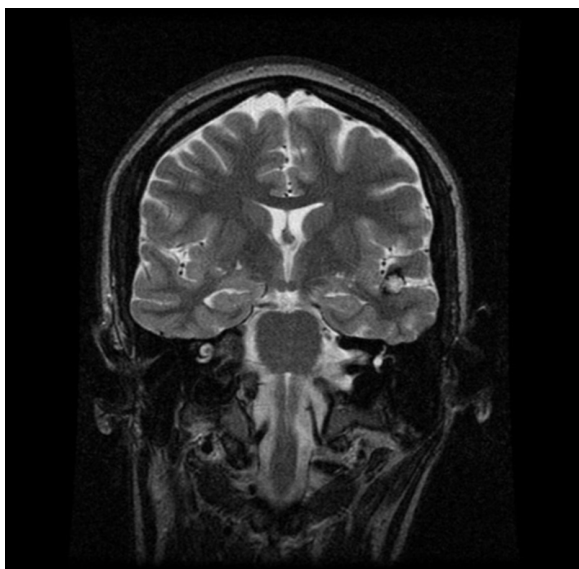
Brain MRI demonstrating a left lateral temporal cavernous vascular malformation in a patient following a first seizure
